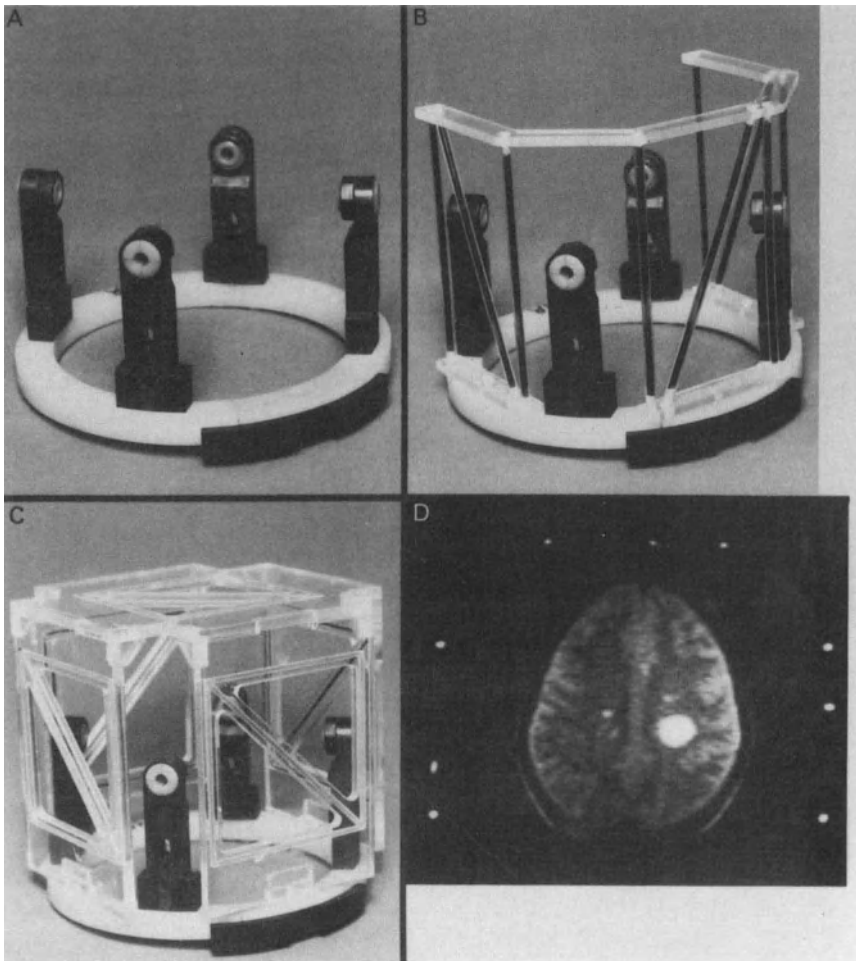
(A) MRI compatible head holder. (B) Transverse MRI localization system. (C) Multiplanar localization system. (D) (Stereotactic) MRI demonstrating nine reference marks.
